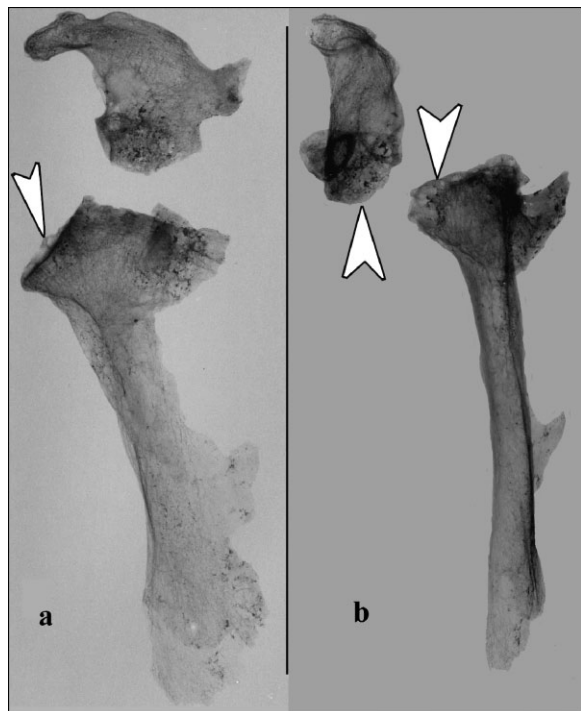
(a) Anterior-posterior radiograph and (b) medial-lateral radiograph of left scapula. Arrows mark areas of disorganised bone on glenoid fossa.
